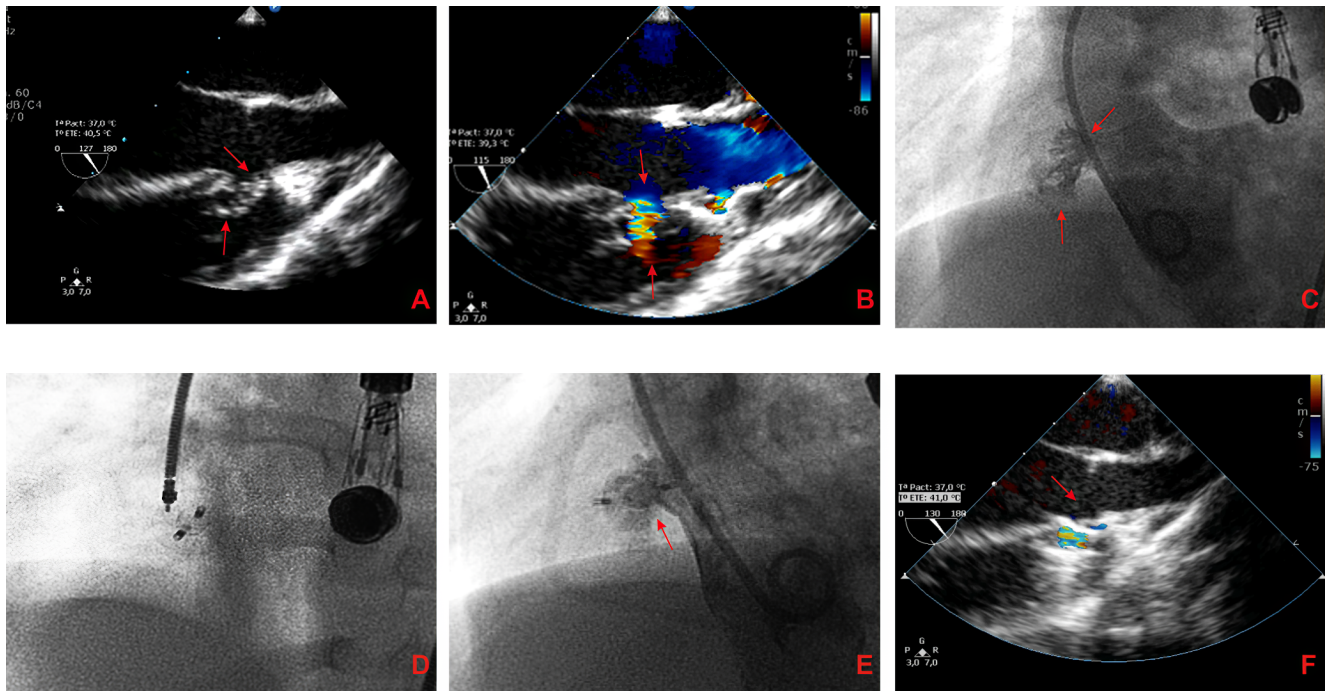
Perimembranous VSD. *Panel A.* TEE 120 degrees view. The arrows show the VSD. *Panel B.* TEE 120 degrees with Doppler color where the arrow shows the flow of the color through the VSD. *Panel C.* Left Ventricular Angiography (4 chambers): the arrow shows the VSD. *Panel D.* Retrograde approach positioning of the device. *Panel E.* Left Ventricle Angiography (4 chambers): the arrow shows the correct position of the device. *Panel F.* TEE 120 degrees view that shows the trivial residual shunt.
